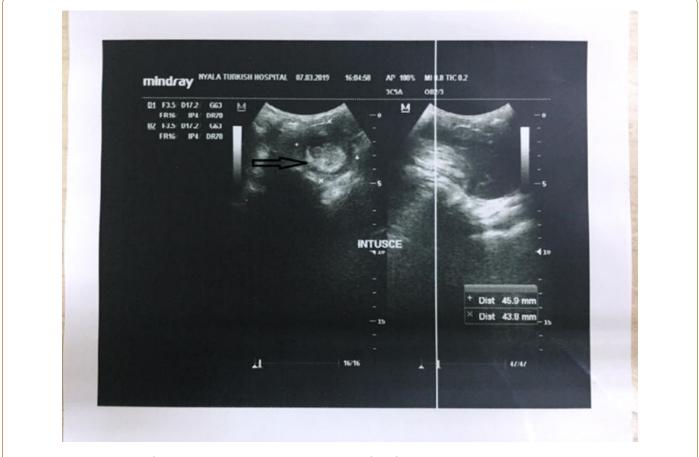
The ultrasound of the abdomen showed mild interbowel-free fluid, dilated bowel loops and target sign.
